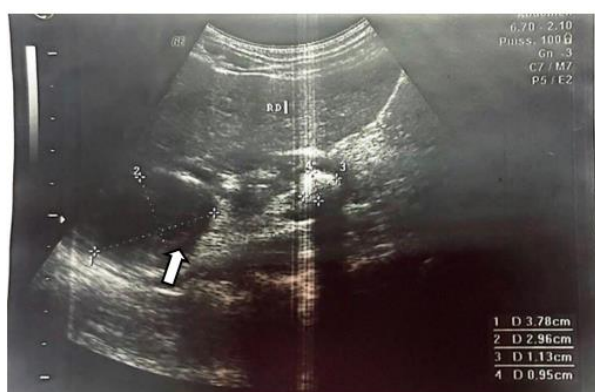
Ultrasound image showing a right renal hydatid cyst
